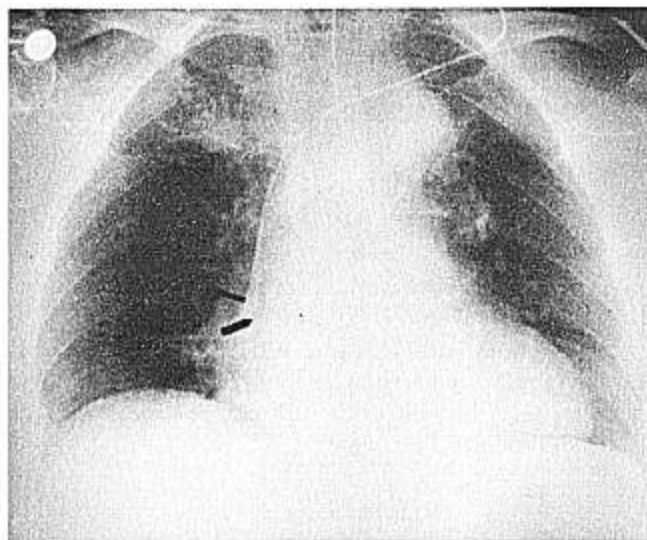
Chest roentgenogram of the patient in figure 1 with an 8-inch catheter inserted through the left external jugular vein. The arrow indicates the catheter's tip, the line marks the pericardial reflection. This longer catheter allows its terminal portion to turn caudally into the superior vena cava, so that the tip does not abut directly against the venous wall.
